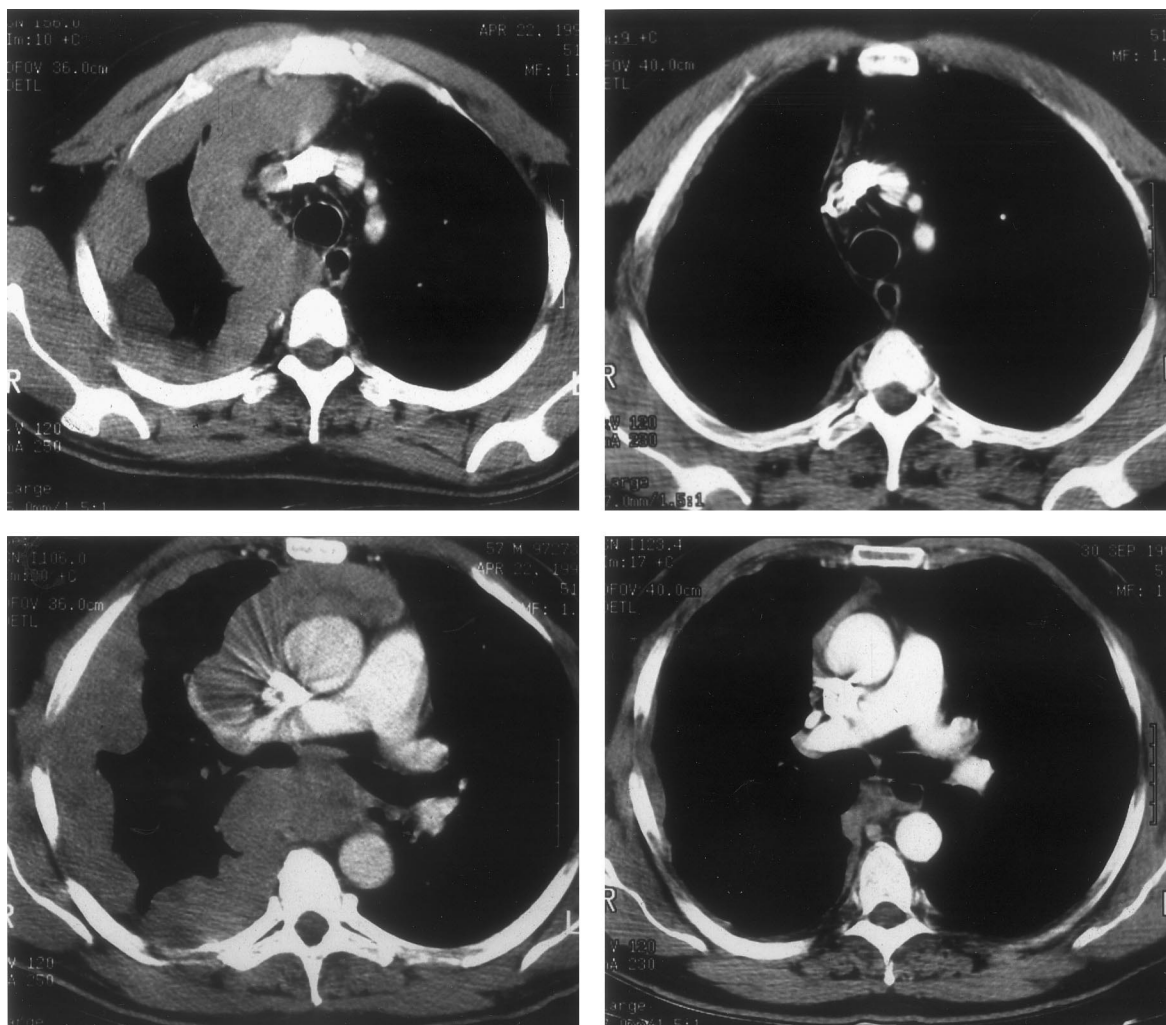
Chest computed tomography (CT) scan of a patient with malignant mesothelioma before (left) and 3 months after (right) raltitrexed–oxaliplatin combination.
